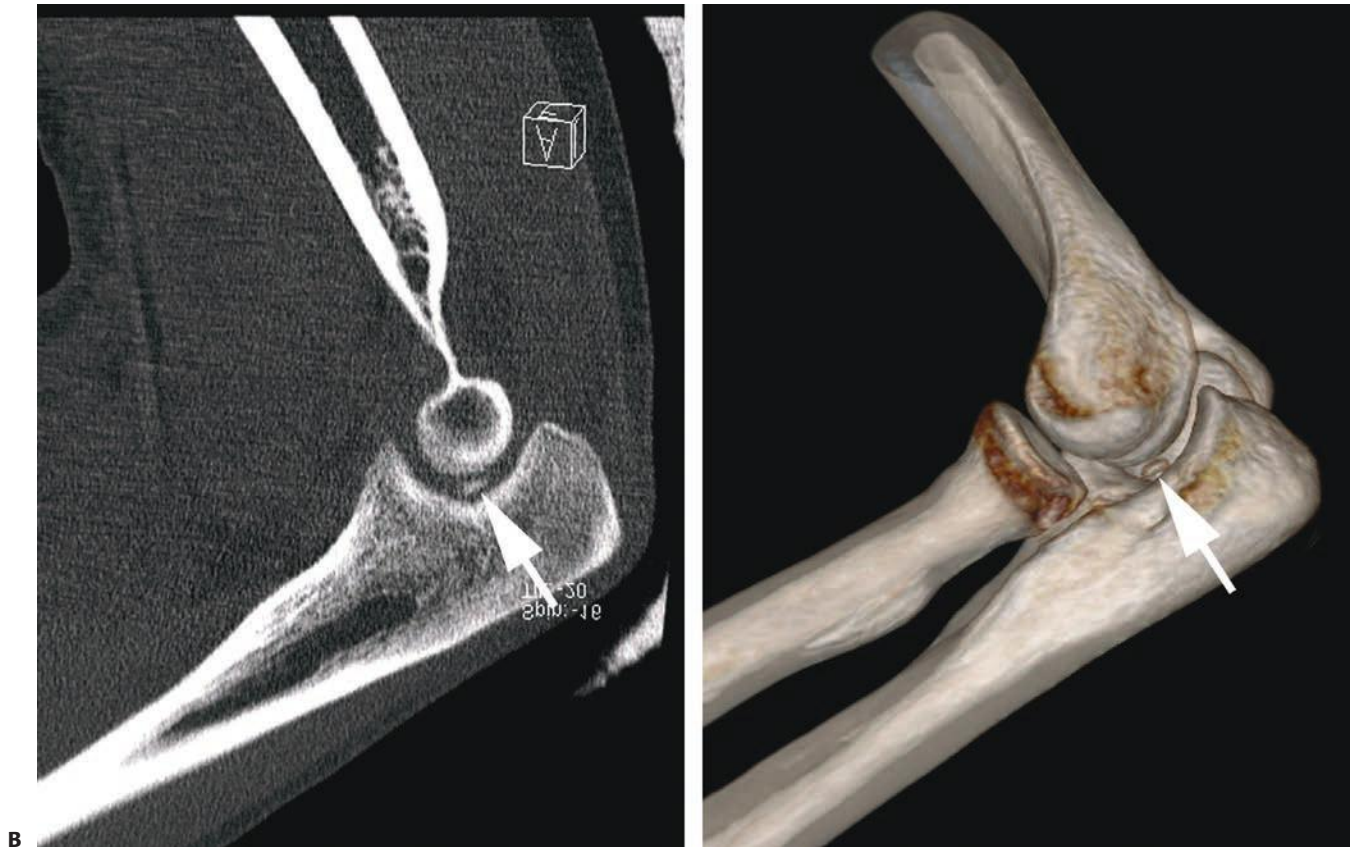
(continued) B: Following successful closed reduction, fluoroscopic images suggested an entrapped intra-articular osteochondral fragment (*arrow*). This was confirmed with a CT scan. She subsequently underwent early open removal of these fragments via a medial approach. Significant damage was noted to the brachialis musculature.
